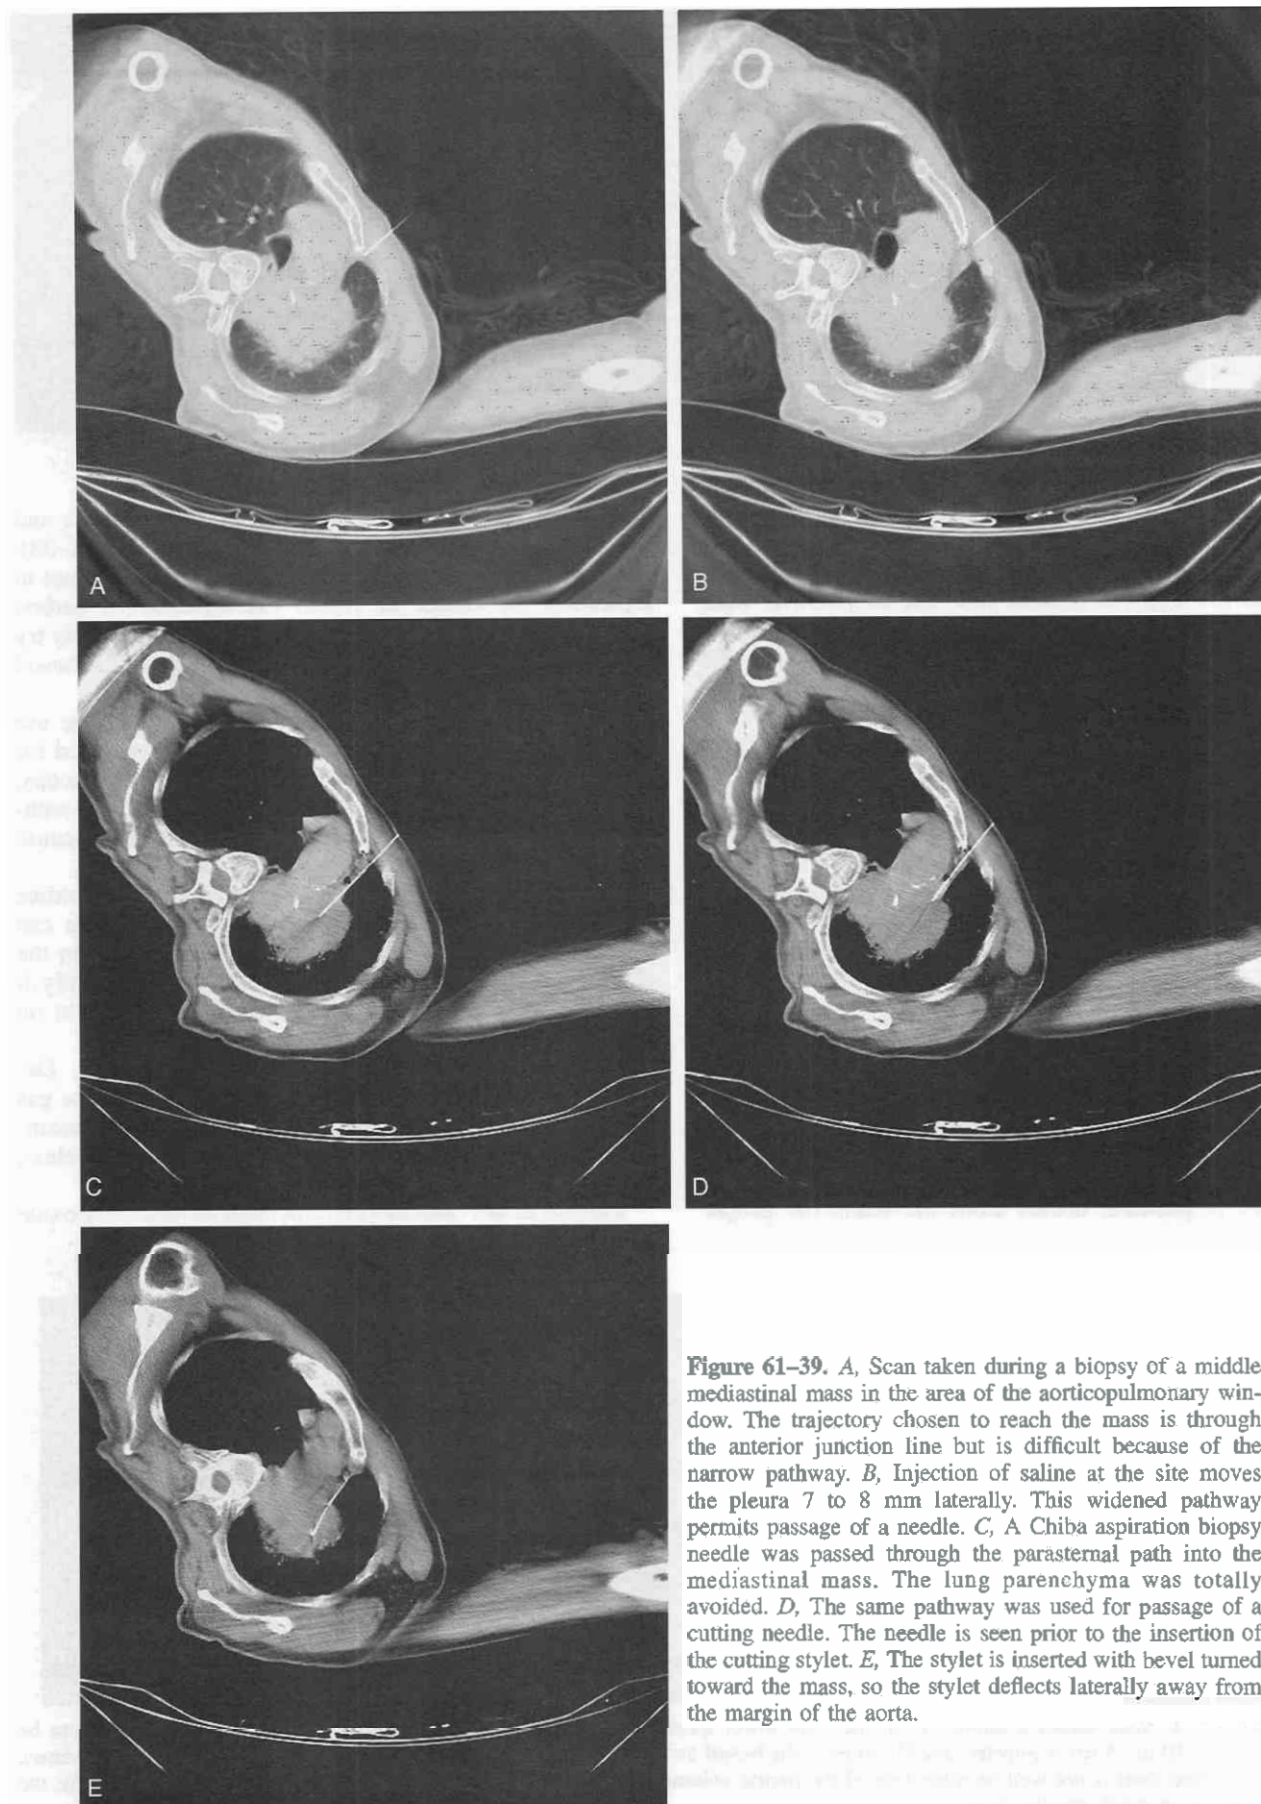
A, Scan taken during a biopsy of a middle mediastinal mass in the area of the aorticopulmonary window. The trajectory chosen to reach the mass is through the anterior junction line but is difficult because of the narrow pathway. B, Injection of saline at the site moves the pleura 7 to 8 mm laterally. This widened pathway permits passage of a needle. C, A Chiba aspiration biopsy needle was passed through the parasternal path into the mediastinal mass. The lung parenchyma was totally avoided. D, The same pathway was used for passage of a cutting needle. The needle is seen prior to the insertion of the cutting stylet. E, The stylet is inserted with bevel turned toward the mass, so the stylet deflects laterally away from the margin of the aorta.
